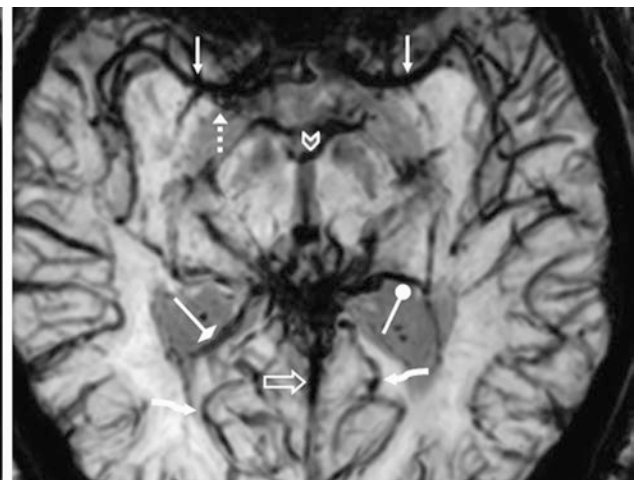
In this 51-year-old, 3 T SWI MRI at 15 mm thickness demonstrates normal veins, with asymmetry of the right deep MCV (*dotted arrow*) and the left BVR (*short white arrows*). (The MCAs [*thin arrows*] are also dark owing to technique.) Note an interpeduncular or anterior ponto-mesencephalic vein (*chevrons*), a left direct lateral vein
